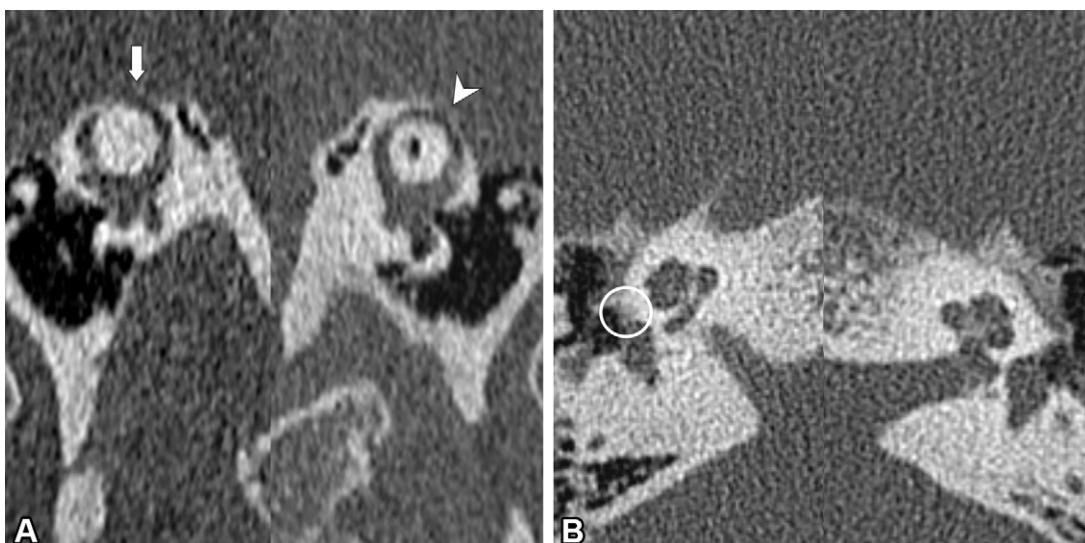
Superior semicircular canal dehiscence and fenestral otosclerosis in a 42-year-old woman with right-sided conductive hearing loss and bilateral tinnitus after recovery from an upper respiratory infection. (A) CT image of the temporal bone in the Pöschl plane shows dehiscence of the right superior semicircular canal (arrow) and thinning of the left superior semicircular canal (arrowhead). (B) Axial CT image of the temporal bone shows subtle lucency in the right otic capsule (circle) along the anterior aspect of the right oval window in the region of the fissula ante fenestram, consistent with fenestral otosclerosis. The patient opted for conservative management with use of hearing aids, which improved her symptoms.
